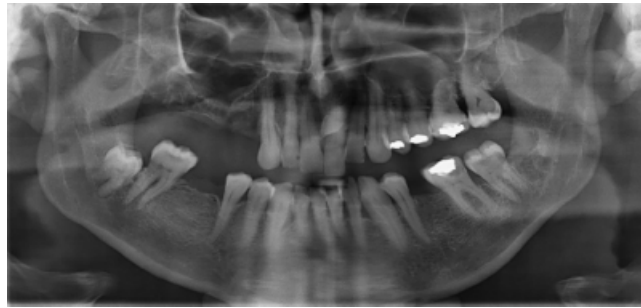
Orthopantomogram revealing caries profunda in multiple teeth and severe periodontal break down.
